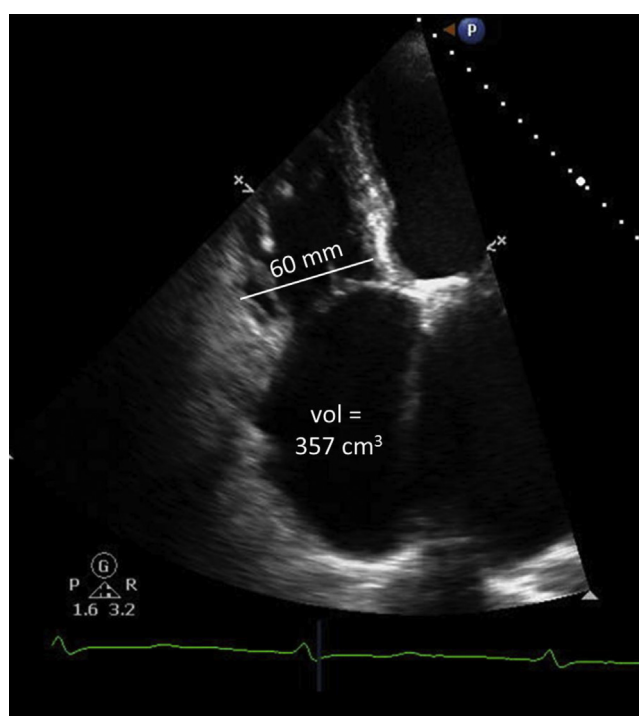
Apical transthoracic echocardiography imaging demonstrating right heart enlargement.
